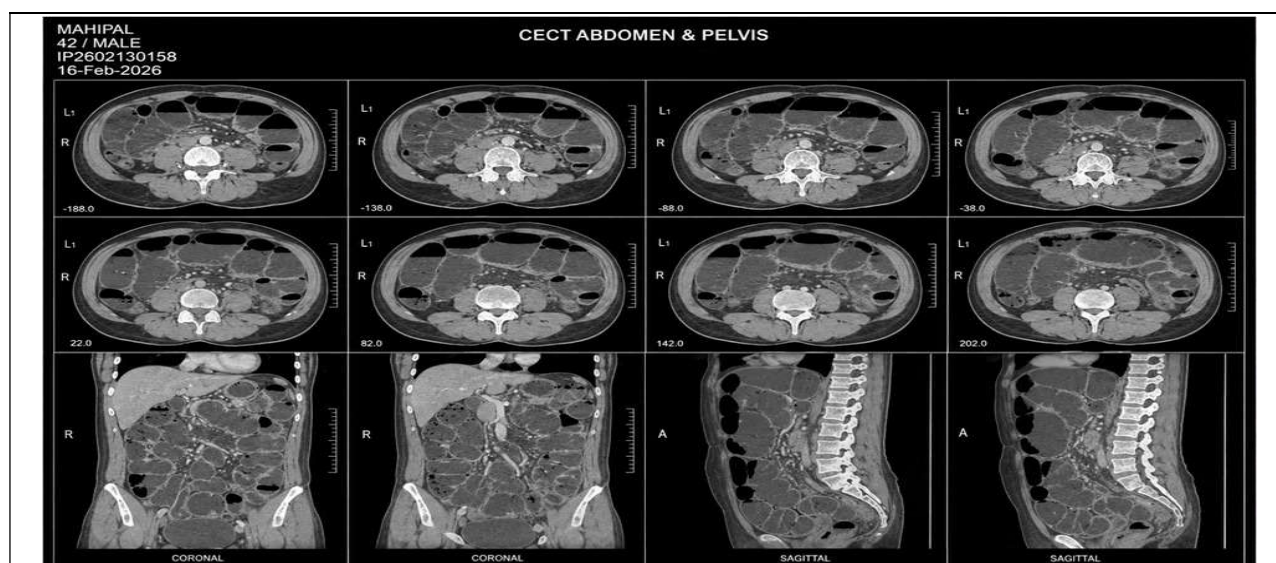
Axial contrast-enhanced CT image showing diffuse bowel dilatation without a transition point
